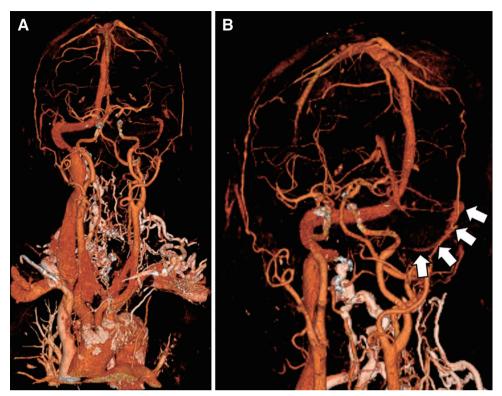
3D CTA finding 1 month after the discharge. Right IJV, right sigmoid sinus, and right TSS and SSS were enhanced, but left IJV was not enhanced (A). Compared with right sigmoid sinus and right TSS, left sigmoid sinus (arrows) was barely enhanced and left TSS was not enhanced (B). IJV: internal jugular vein; SSS: superior sagittal sinus; TSS: transverse sinus
